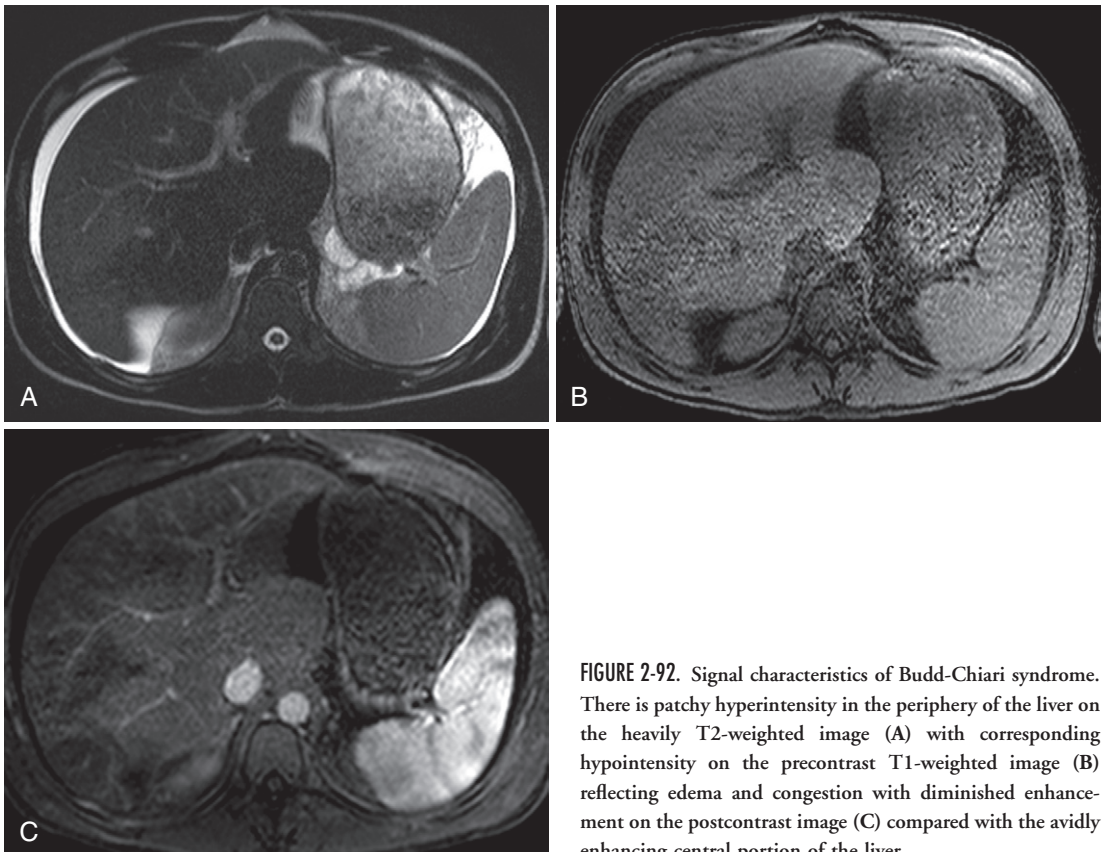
Signal characteristics of Budd-Chiari syndrome. There is patchy hyperintensity in the periphery of the liver on the heavily T2-weighted image (A) with corresponding hypointensity on the precontrast T1-weighted image (B) reflecting edema and congestion with diminished enhancement on the postcontrast image (C) compared with the avidly enhancing central portion of the liver.
